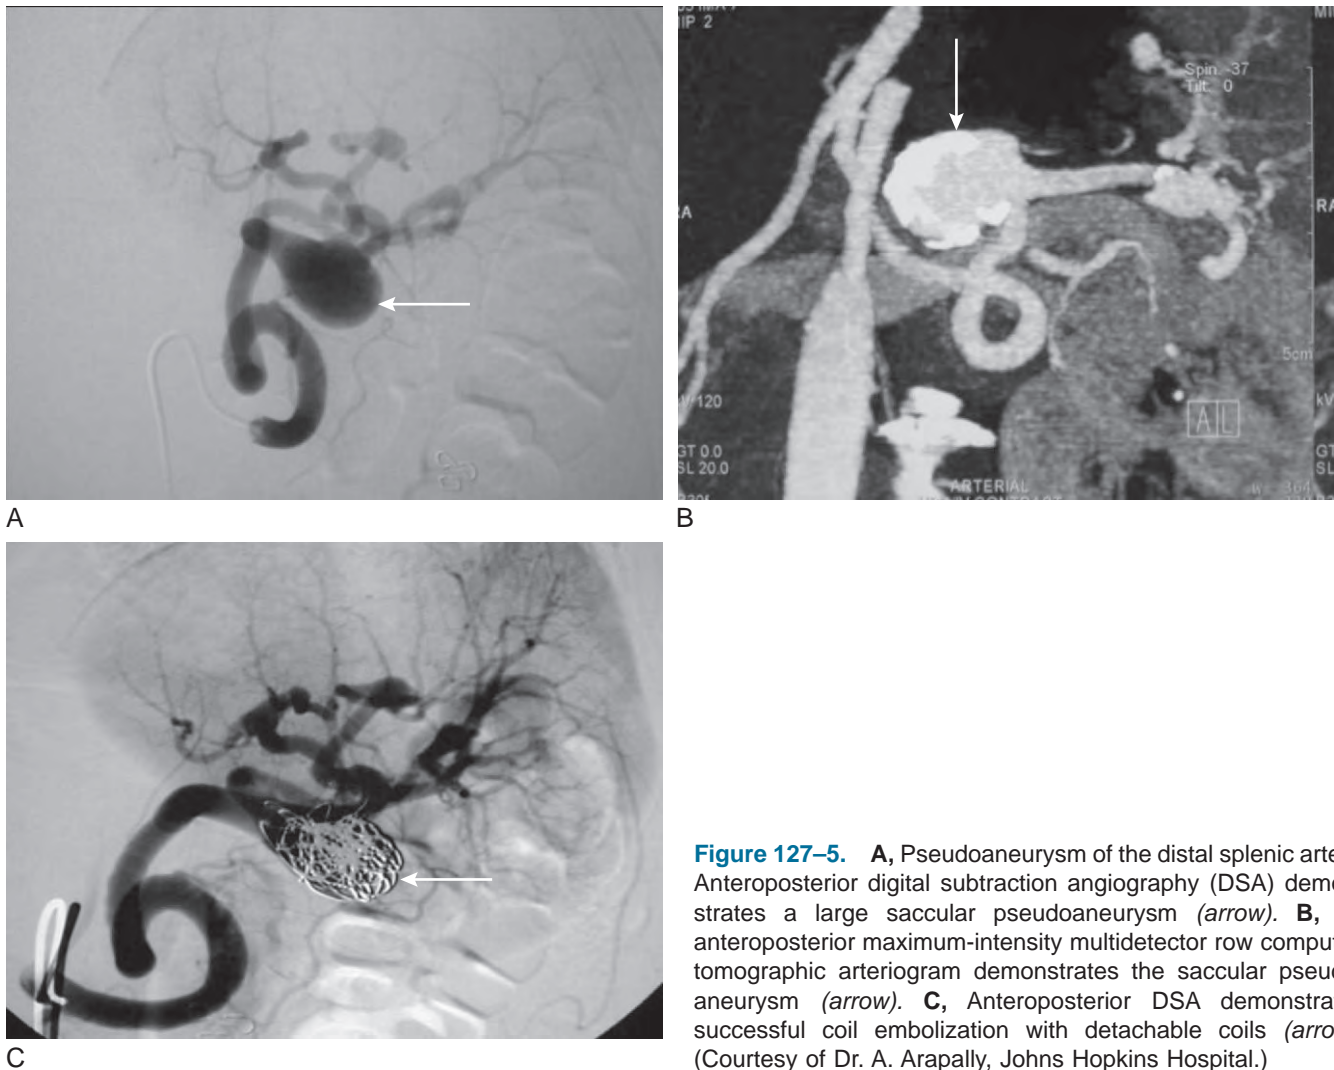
A, Pseudoaneurysm of the distal splenic artery. Anteroposterior digital subtraction angiography (DSA) demonstrates a large sacular pseudoaneurysm (*arrow*). B, An anteroposterior maximum-intensity multidetector row computed tomographic arteriogram demonstrates the sacular pseudoaneurysm (*arrow*). C, Anteroposterior DSA demonstrates successful coil embolization with detachable coils (*arrow*). (Courtesy of Dr. A. Arapally, Johns Hopkins Hospital.)
